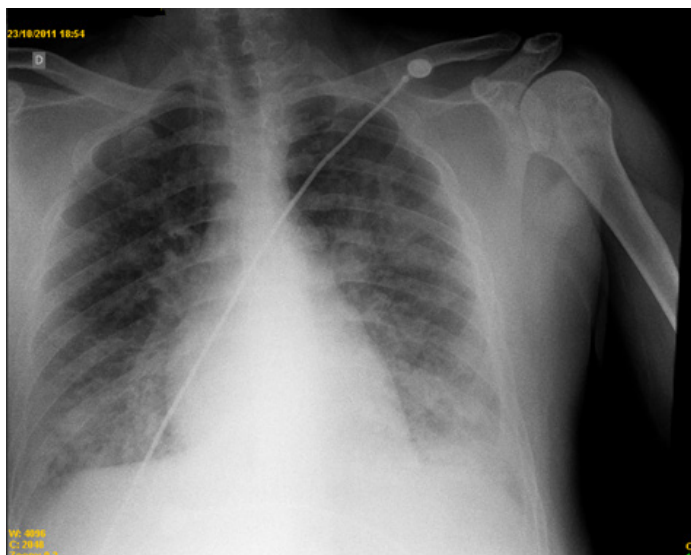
PA Chest X-ray PA: bilateral alveolar infiltrate.
